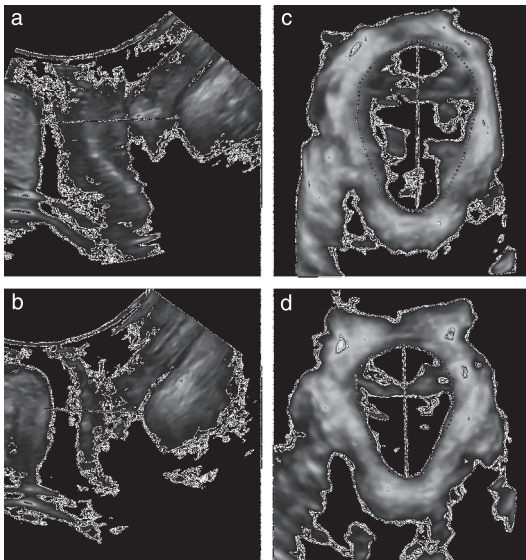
Sonographic images of intact levator ani muscle. (a,b) Two-dimensional images in midsagittal view in plane of minimal hiatal dimensions, showing anteroposterior levator hiatus diameter from distal border of pubic symphysis to puborectalis muscle (lines) at rest (a) and on contraction (b). (c,d) Three-dimensional images showing anteroposterior hiatal diameter and area (solid lines and dotted lines, respectively) at rest (c) and on contraction (d).
